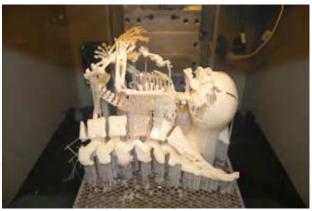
34 weeks Physical model of fetus built from CT scan through SLA process (3D systems – VIPER Si).
